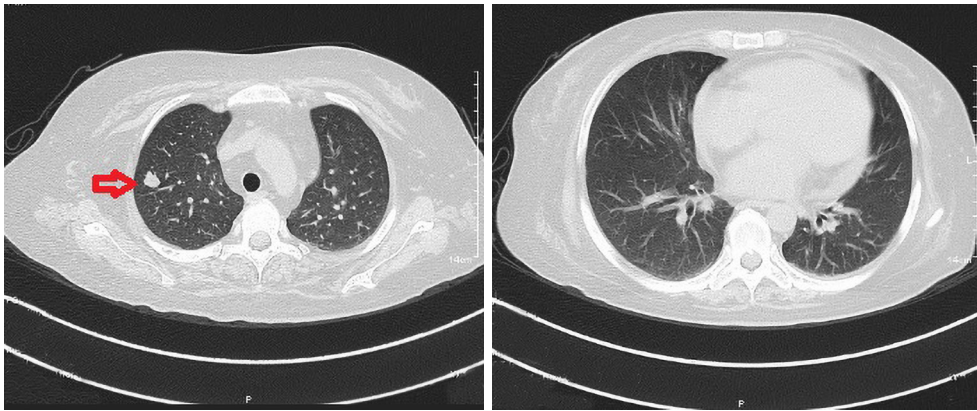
Plain lung CT scan. The red arrow indicates a new solid nodules in the right upper lobe. CT, computed tomography.
